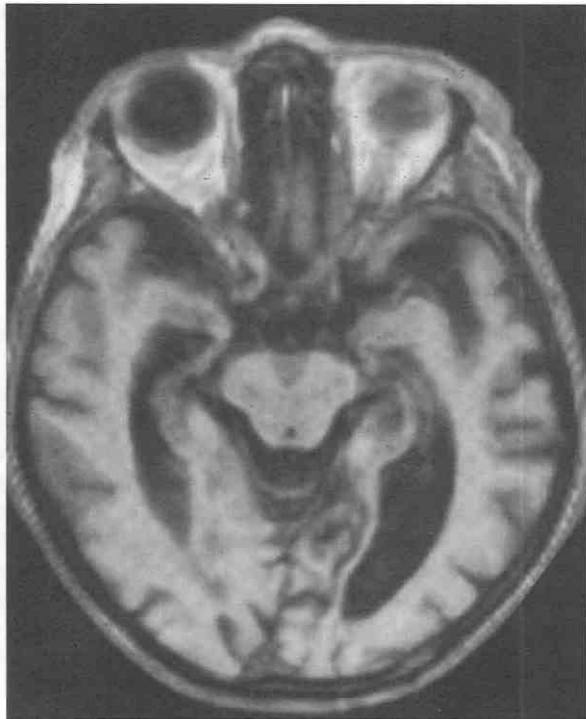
Clinical Alzheimer's disease in a woman. Reverse-angle axial T1-weighted MR image (Global Deterioration Scale = 5). There is decreased signal intensity between the temporal horns and the perimesencephalic cistern. This represents dilatation of the perihippocampal fissures (PHFs) and atrophy of the structures of the medial temporal lobe, including the hippocampus. The size of the PHFs was assessed as moderately dilated. Compare with Figures 10-11 and 10-12. (From Holodny AI, Waxman R, George AE, et al: MR differential diagnosis of normal-pressure hydrocephalus and Alzheimer disease: Significance of the perihippocampal fissures. *AJNR Am J Neuroradiol* 19:813-819, 1998.)
